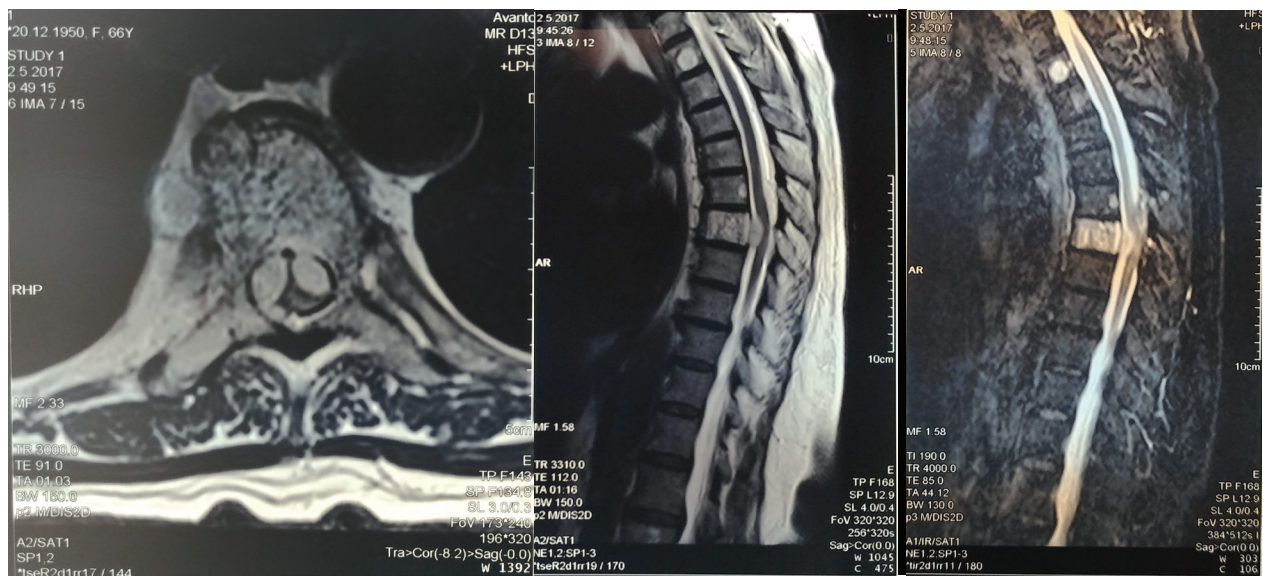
Left and middle: MRI axial and sagittal cross-section in the T2W sequence show an inhomogeneously elevated signal intensity with the capture of the posterior elements to the right and the epidural spreading on both sides and compression of the anterior aspect of the spinal cord. Right: The lesion shows a significant increase in the intensity of the signal postcontrast. Oval changes in similar MRI characteristics in Th2 and Th6 vertebral bodies are also visible.
